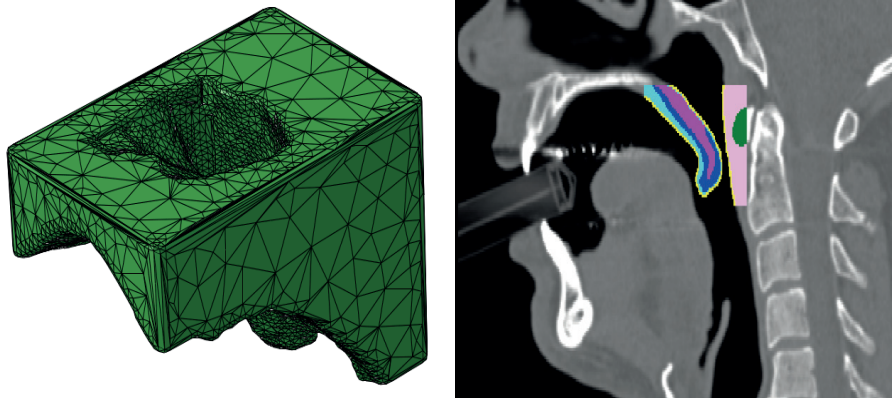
3-D mesh of the velopharynx used in the FE model (left) and CT image with colour plot of the anatomical boundaries (right).
